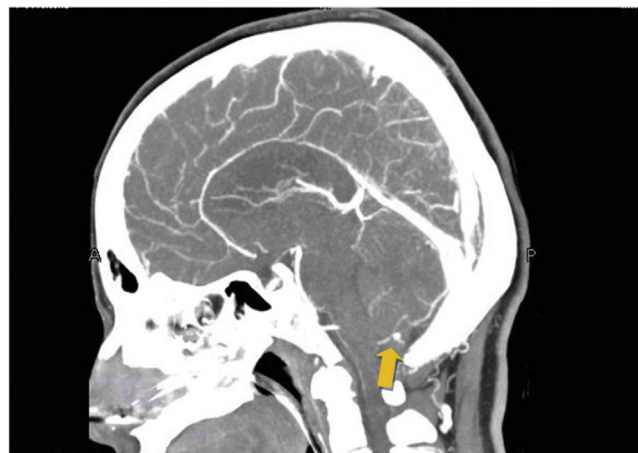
Sagittal view on CT scan: Presence of suspected aneurysm. Orange arrow points to the aneurysm.
